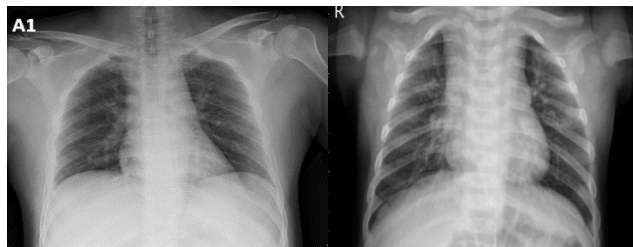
Example of chest X-ray image of COVID-19 (left) and SARS (right) [8].
